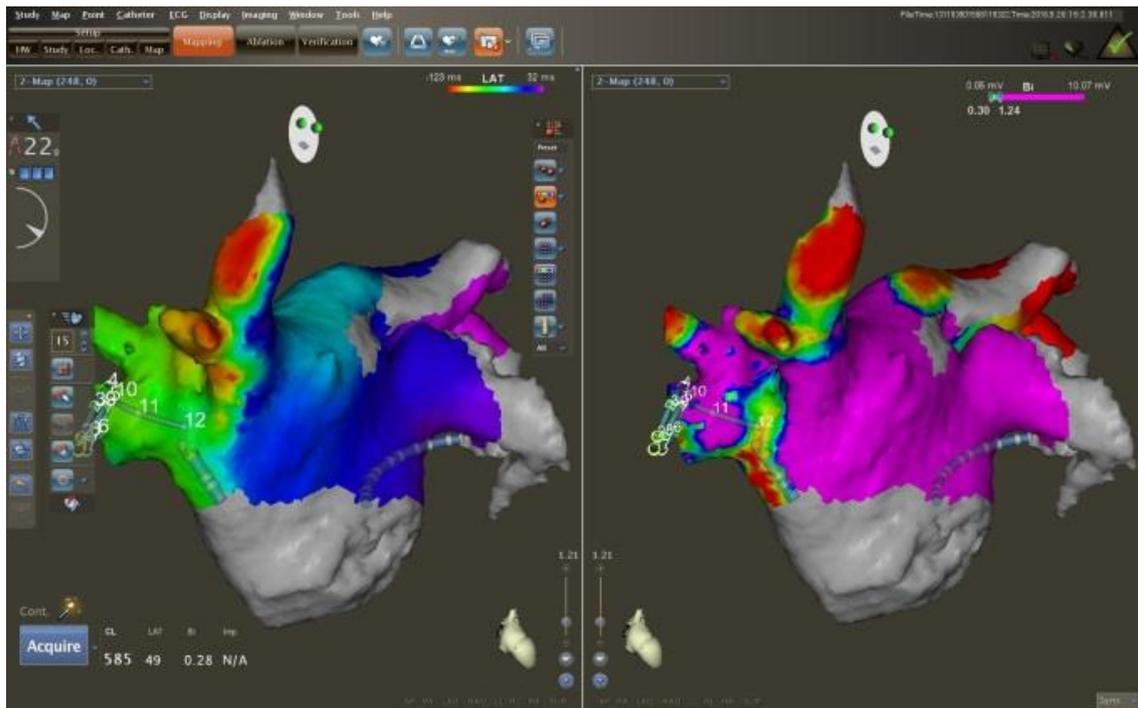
Atrial tachycardia after previous pulmonary vein isolation. Electroanatomical activation map (left side) and voltage map (right side) of the left atrium, performed with the CARTO system and CT-Merge. The AT originates from the right superior pulmonary vein; the site of reconnection is at the infero-anterior part of the vein. Electrophysiology Laboratory, Heart and Vascular Center, Semmelweis University.
